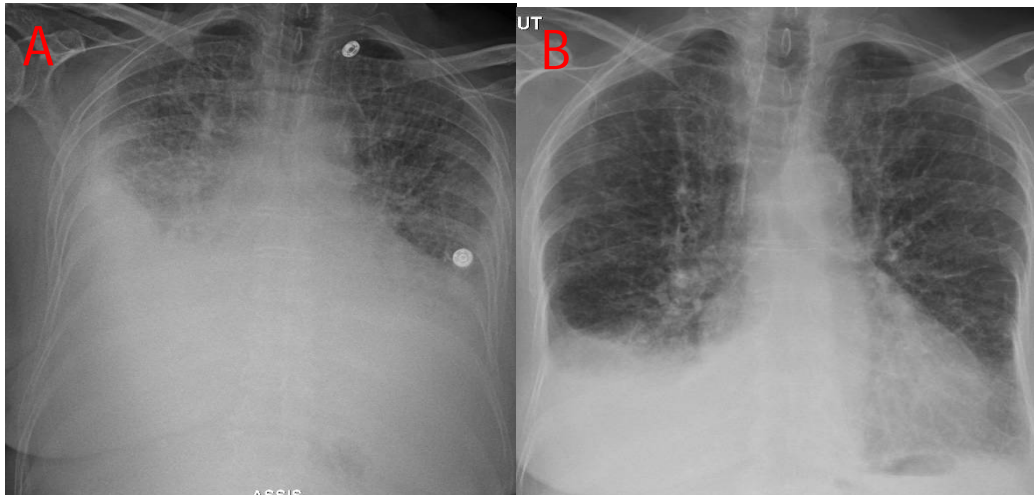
chest X-ray:A- showing bilateral pleural effusion more important on the left lung associated with interstitial syndrome. B-Regression of pleural effusion after puncture with removal of 750ml on the left pleural space and 650ml on the right pleural space respectively.
